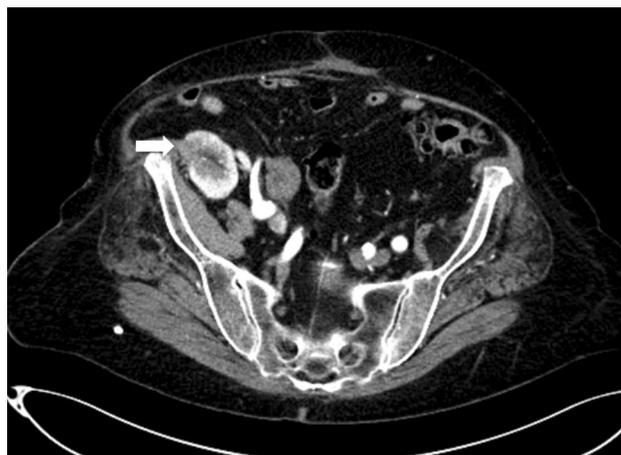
Case 1: post-operative ce-CT scan demonstrating complete tumour ablation (white arrow)
